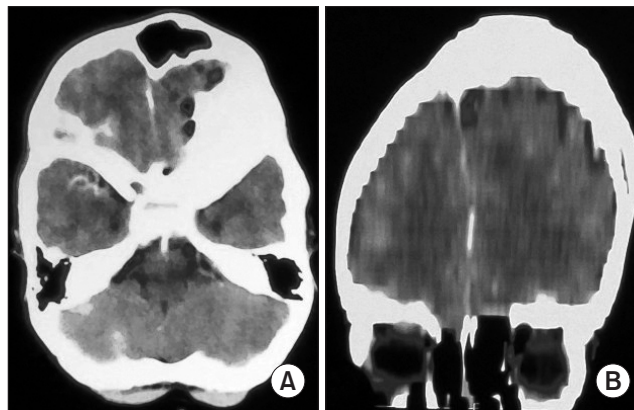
Computed tomography image of the brain showing left frontal sinus enlargement, thickening of the squamous part of the temporal bone (A), and mild elevation of the left orbital roof (B).
